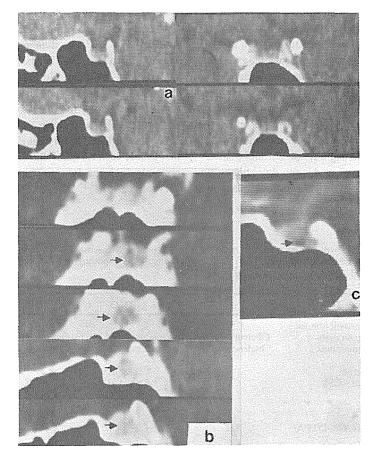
(a) – normal sella on the postcontrast CT scans in sagittal and coronal planes: (b) – a low-density lesion < 10 mm in the anterior and lateral part of the pituitary gland in both planes (prolactinoma – arrow); (c) – pars intermedia cyst (arrow).
